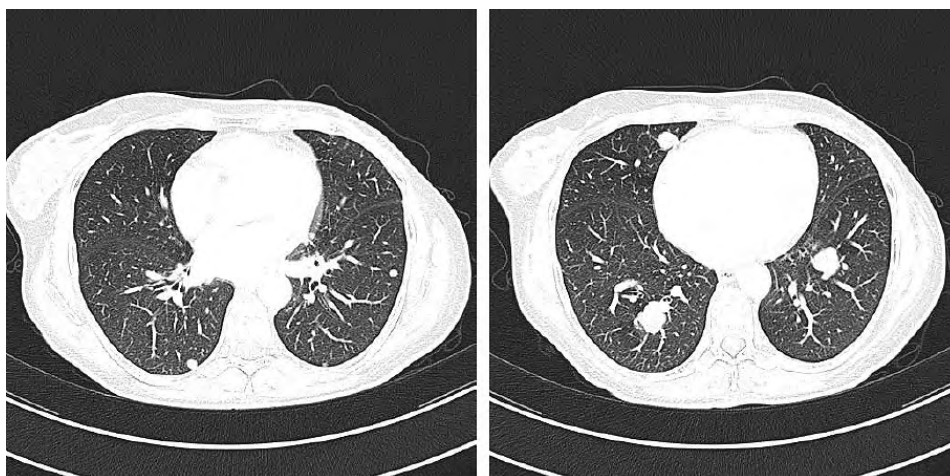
Computed tomography scan — October 2022
